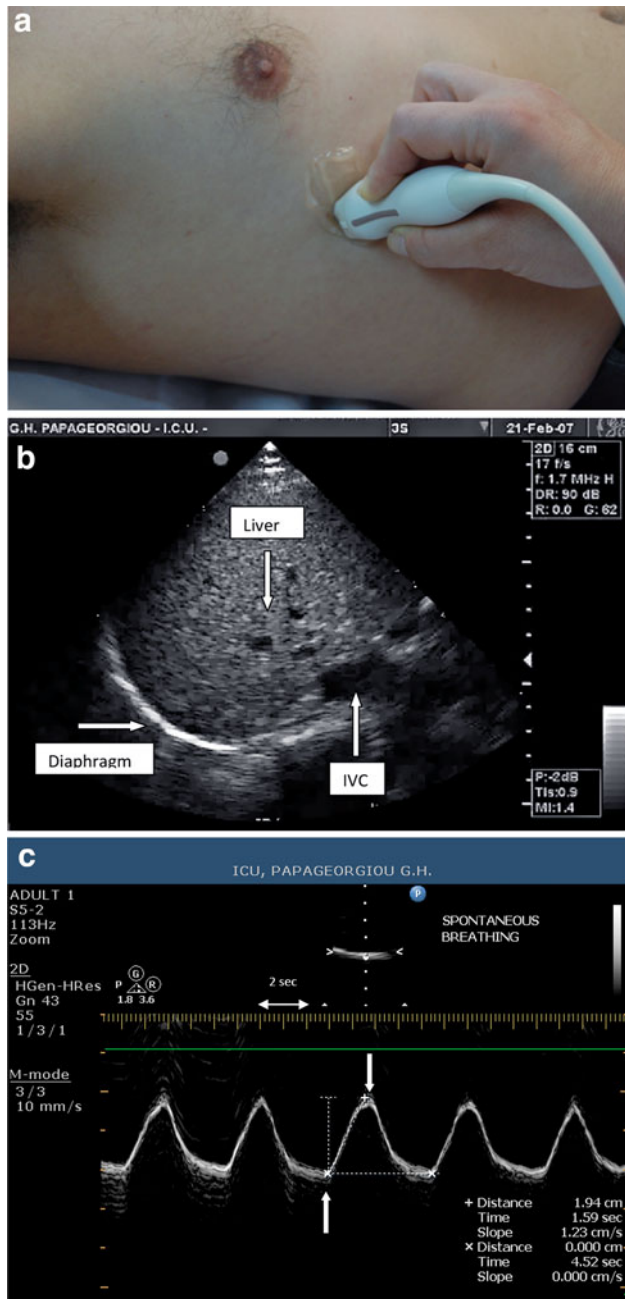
a Probe position for B and M mode diaphragmatic excursion measurements with 3.5–5 MHz probe. b B-mode diaphragm sonography. The *bright line* reflects the diaphragm. c M-mode diaphragm sonography. *Arrows* indicate the beginning and the end of the diaphragmatic contraction. The distance between the *arrows*, indicate an excursion (displacement) of 1.9 cm. The inspiratory time (T_{insp}) is measured at 1.6 s, the cycle duration (T_{tot}) is 4.5 s, and the speed of diaphragmatic contraction (slope), calculated as the diaphragmatic excursion divided by the T_{insp}, is 1.2 cm/s
